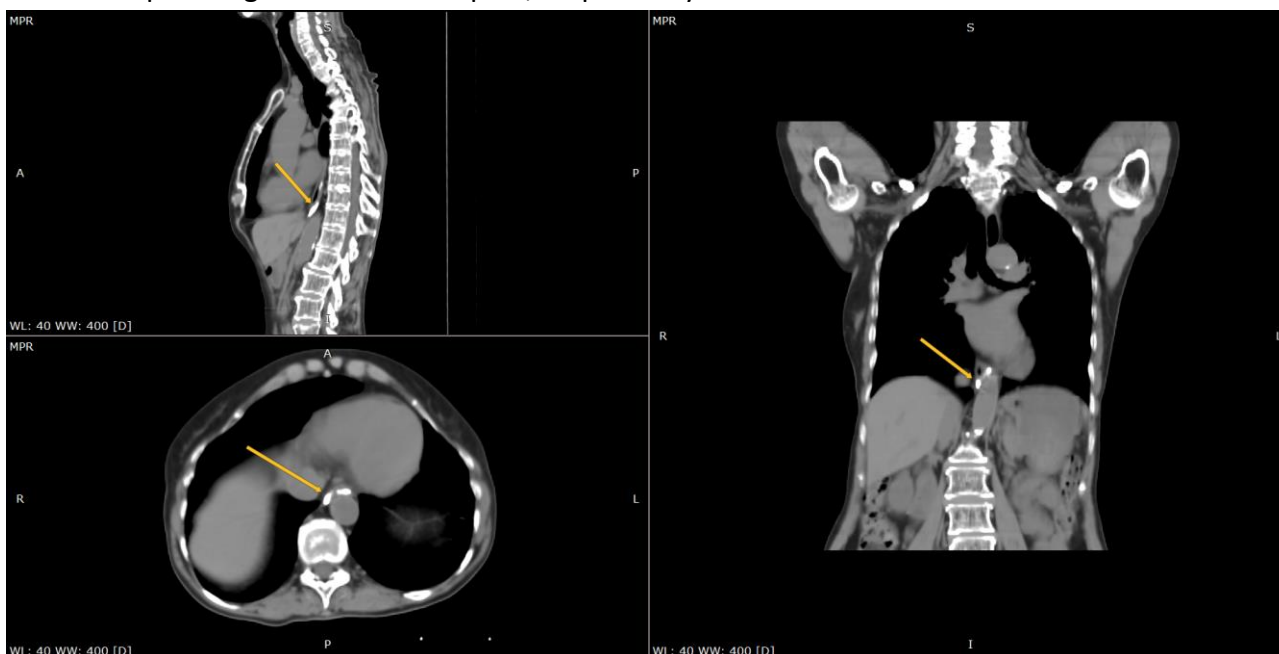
BioXmark® (yellow arrow) in the esophagus on planning CT.
